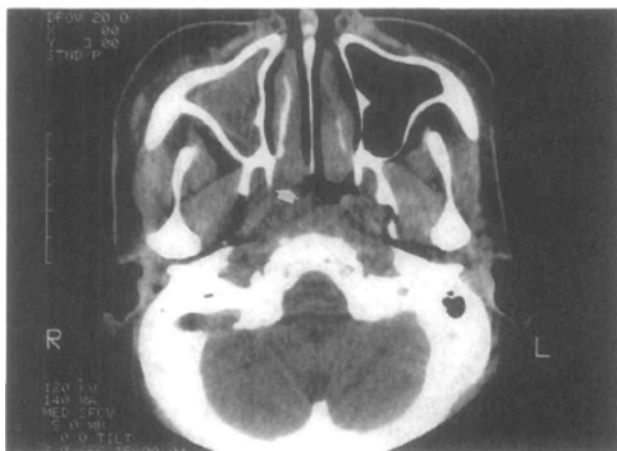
Axial CT scan at the level of nasopharynx showing anatomical distortion of upper airway with obstruction of right posterior choana (arrow).
